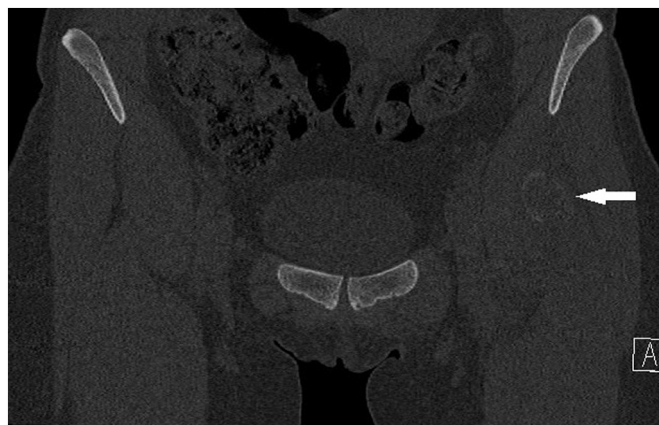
By CT, a diffuse swelling of the proximal rectus femoris muscle with faint peripheral calcifications was seen (Case 8).
